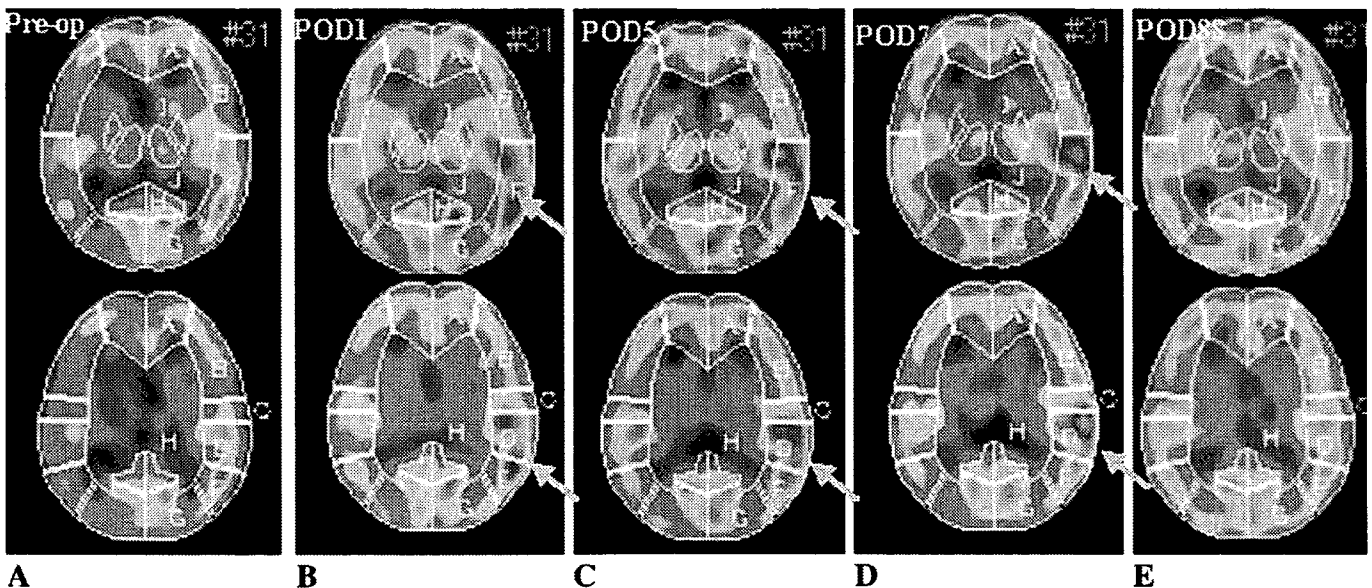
Case 2. ¹²³I-IMP-SPECT scans before surgery (A) and 1 (B), 5 (C), 7 (D), and 88 days (E) after surgery. The transient focal intense increase in CBF at the site of anastomosis (arrows in B-D) was evident as early as 1 day after surgery and preceded the manifestation of motor aphasia on postoperative day 2.
